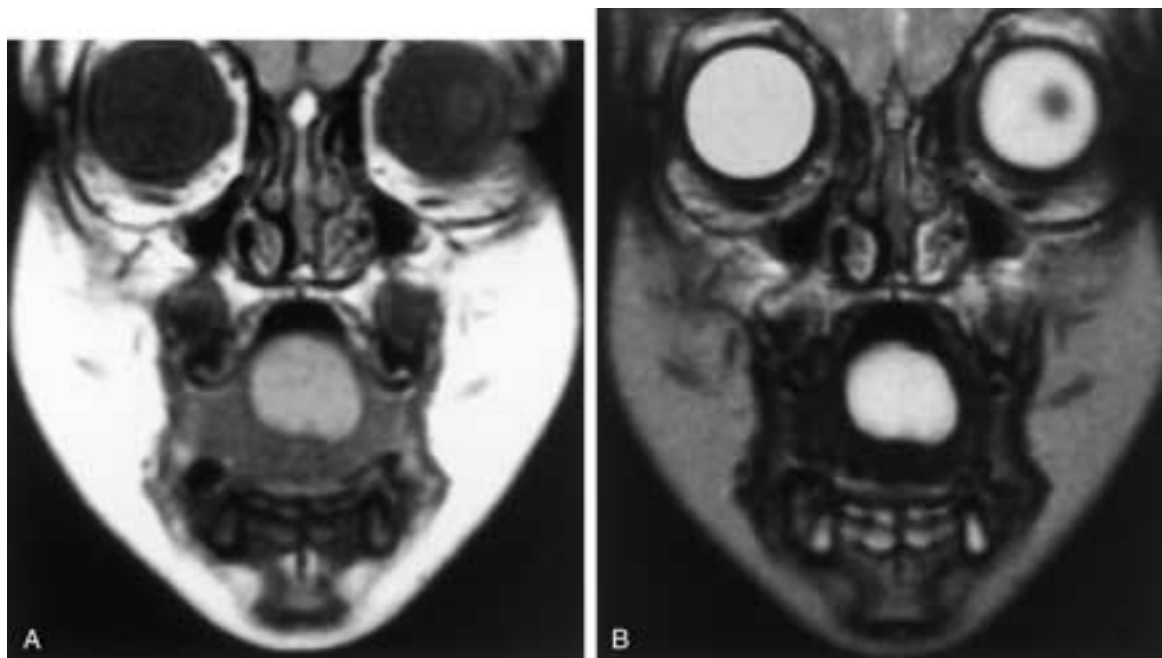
Intralingual cyst of foregut origin in a 3-year-old male. (A) Coronal T1-weighted and (B) T2-weighted MR images demonstrate a well-defined lesion in the dorsum of the tongue. The mild hyperintensity on the T1-weighted image is due to the mucoid content of the cyst.
